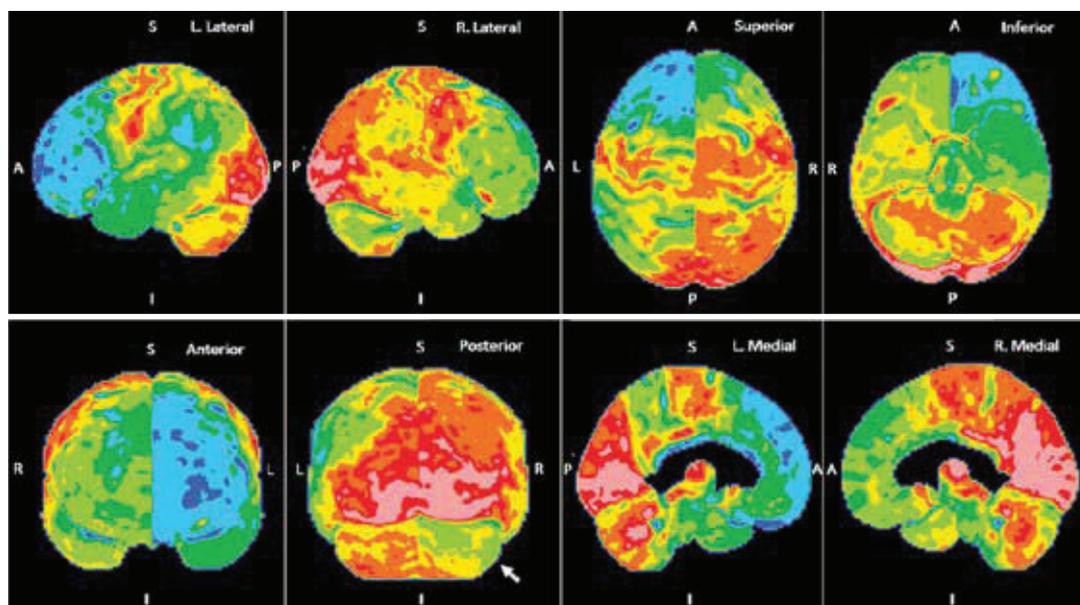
^{18}F -labeled fluoro-2-deoxyglucose positron emission tomography (FDG-PET) 3-dimensional stereotactic surface projection maps of an 86-year-old woman with frontotemporal dementia (behavioral variant) as evidenced by severe left frontal hypometabolism, moderate lateral left temporoparietal hypometabolism, and mild right lateral temporal, frontal and parietal hypometabolism. Note that FDG metabolism (in red) for the precuneus, mesial occipital, and primary motor cortices is normal. In our experience striking left-right asymmetries in FDG metabolism are more common in FTDL dementias. There also is right cerebellar diaschisis (arrow)
